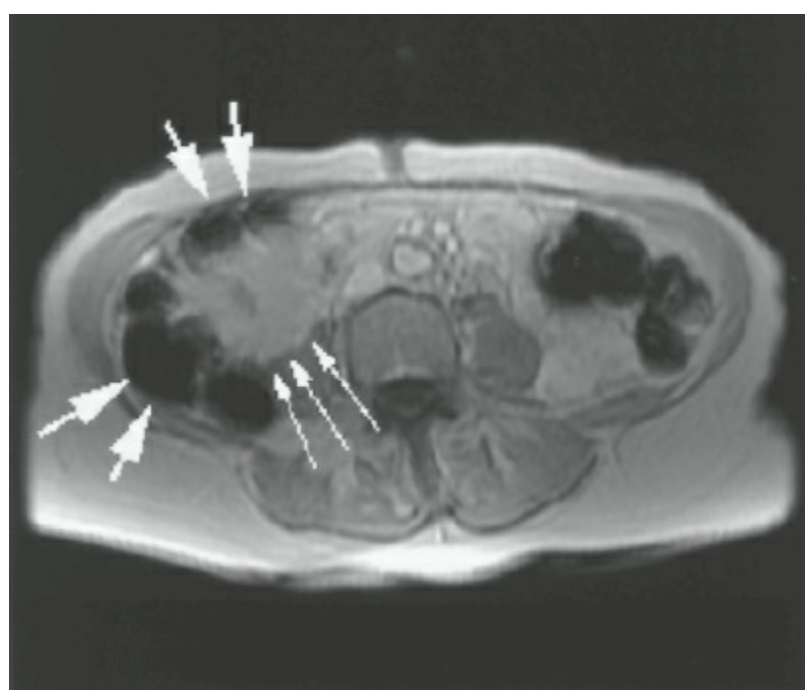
T1-weighted magnetic resonance imaging scan of a patient with gallbladder cancer (*small arrows*) with extension into the duodenum and the hepatic flexure of colon (*large arrows*).
